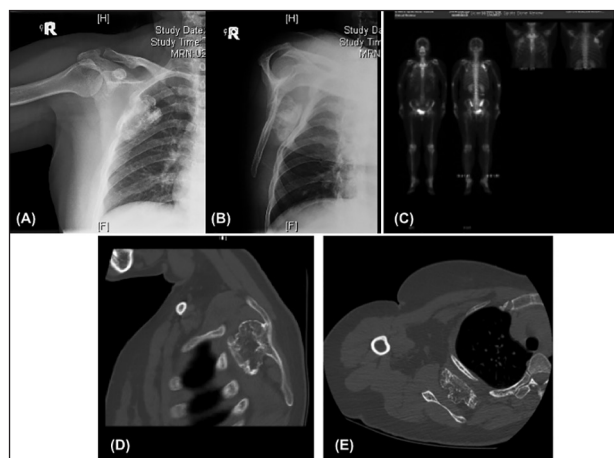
The radiographic study revealed a large bony lesion deforming the medial border of the right scapula. (a) Anteroposterior and (b) lateral view of chest X-ray. The rib cage revealed compression deformity in the third rib. (c) Whole body bone scan revealed an increased technetium-99m diphosphonate scintigram uptake over the right scapula compatible with right scapular mass and a large cauliflower-like osteosclerotic lesion exophytic from the inner area of the right scapular body. (d) Sagittal and (e) transverse view of computer tomographic image revealed the tumor located close and compressed the rib cage
